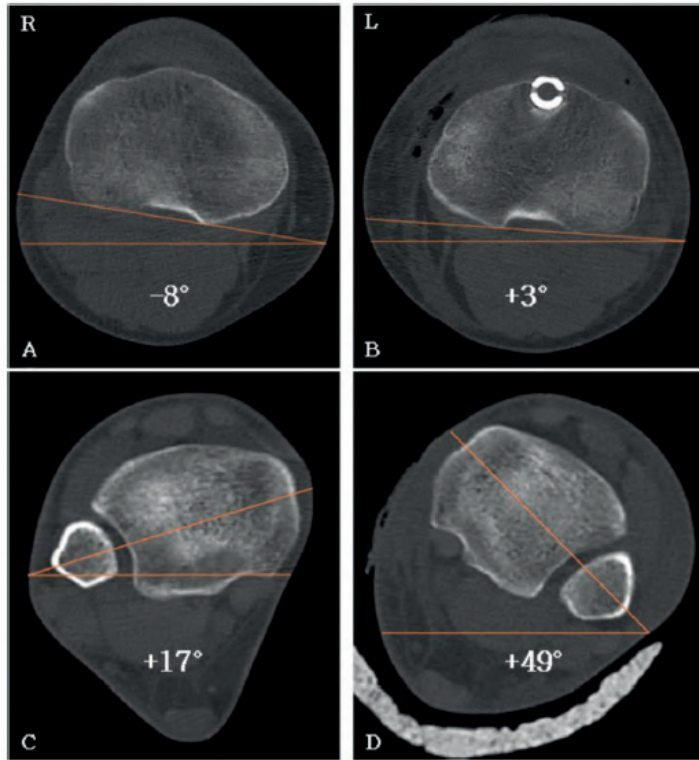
Assessment of post-operative Computed Tomography-slices taken 2-3 mm proximal the tibiofibular and tibiotalar joint of both the affected and unaffected limb. The proximal lines are drawn tangential of the dorsal tibia and the distal lines are drawn through the middle of the tibia and fibula. A and C are the angles of the healthy side and B and D are the angles of the injured side. The rotational difference of the healthy side is 25° (17° (A) - -8° (C)) and the rotational difference in the affected side is 46° (49° (B) - 3° (D)). The rotational malalignment is calculated by taking the difference between the affected ($+46^\circ$) and unaffected side ($+25^\circ$). This means a rotational malalignment of $+21^\circ$ ($46^\circ - 25^\circ$), which is defined as an external rotational malalignment.
